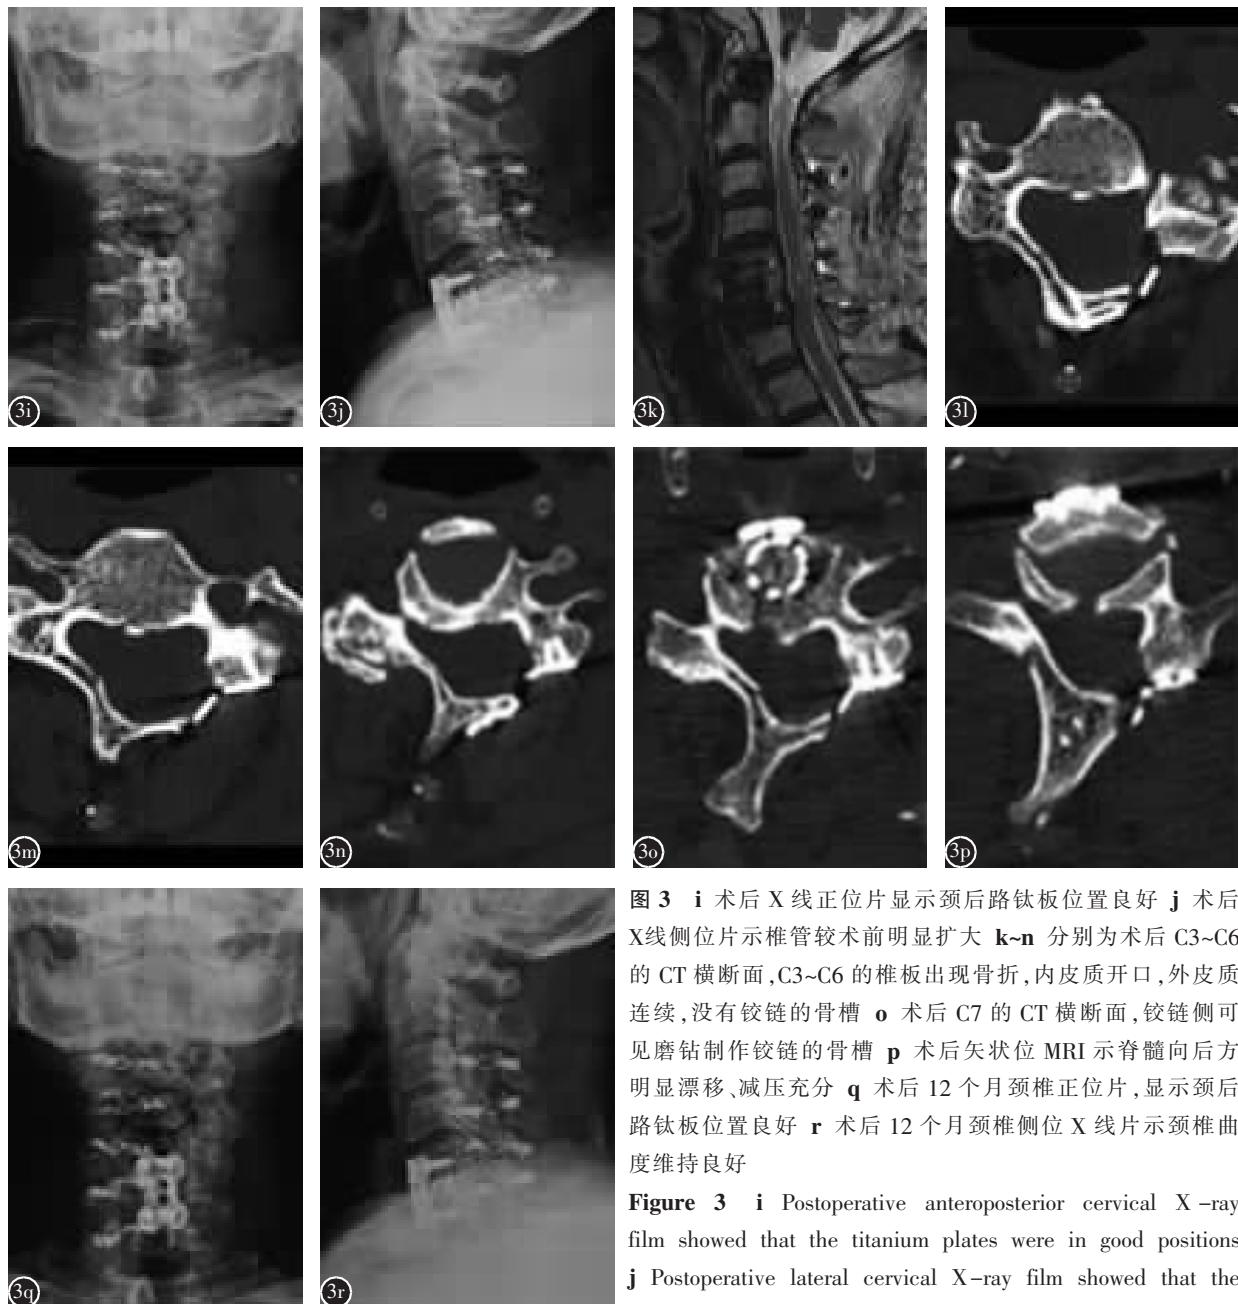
i 术后 X 线正位片显示颈后路钛板位置良好 j 术后 X 线侧位片示椎管较术前明显扩大 k~n 分别为术后 C3~C6 的 CT 横断面，C3~C6 的椎板出现骨折，内皮质开口，外皮质连续，没有铰链的骨槽 o 术后 C7 的 CT 横断面，铰链侧可见磨钻制作铰链的骨槽 p 术后矢状位 MRI 示脊髓向后方明显漂移、减压充分 q 术后 12 个月颈椎正位片，显示颈后路钛板位置良好 r 术后 12 个月颈椎侧位 X 线片示颈椎曲度维持良好
